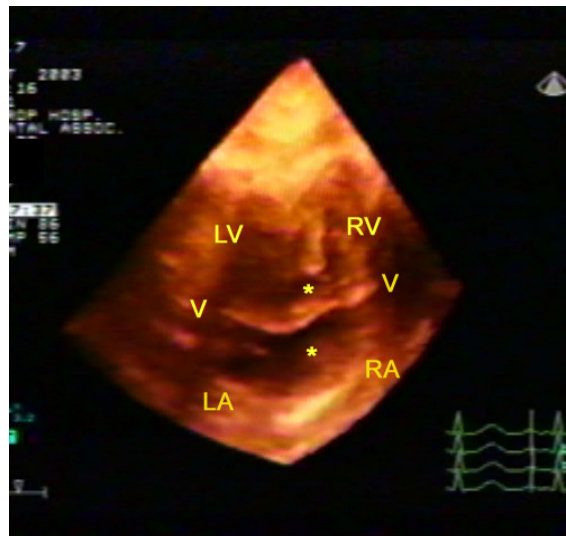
Live 3D echocardiography in 36 week old fetus with complete atrioventricular septal defect. Four chamber views cropped to show the abnormal atrioventricular hemodynamics. (Modified with permission from reference 4)
